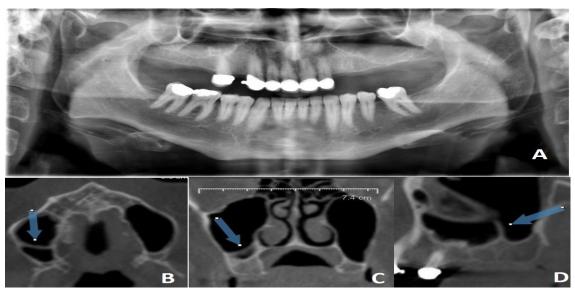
An example of maxillary sinus septa on panoramic (A) and CBCT (B,C and D) images.
